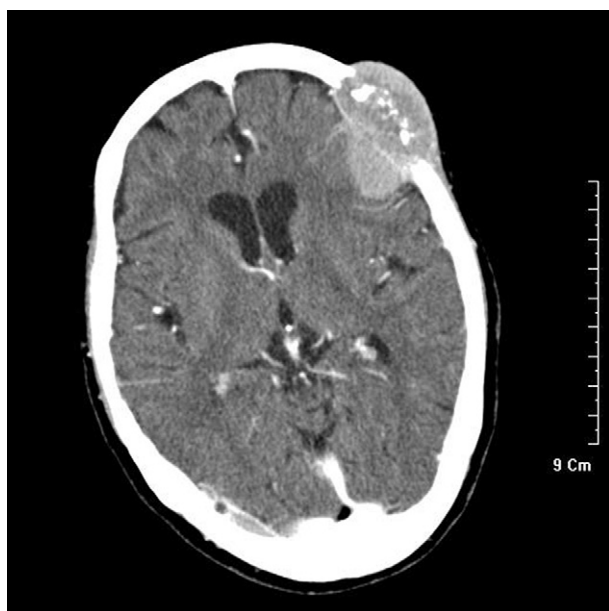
Computed tomography of the brain shows a 5 × 5 cm osteolytic mass in the left frontotemporal area.
